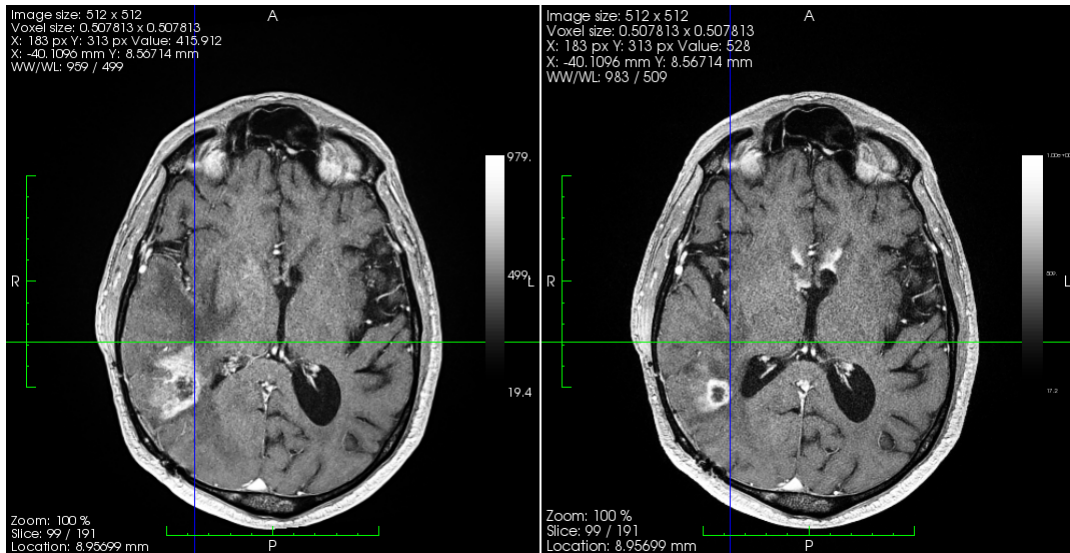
A sample axial slice from baseline (on the right) and follow-up (on the left) MRI.
